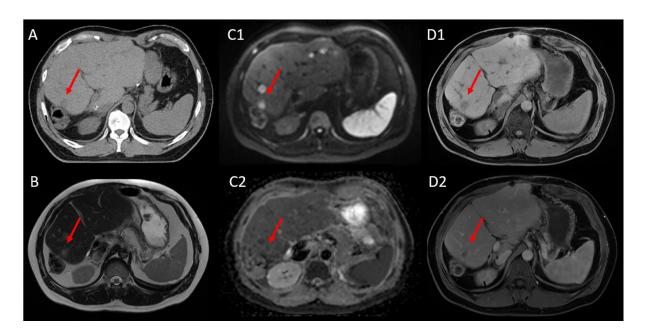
Treatment planning CT (A) and MRI (B-D): A patient with multiple liver metastases. A: native CT scan. B: T2 weighted sequence. C1: Diffusion-weighted Imaging (DWI) at the setting of b=900mm²/s. C2: Apparent Diffusion Coefficient (ADC at b50,900mm²/s). D: T1 weighted sequences with D1: native phase and D2: portal venous phase. Red arrows = demarcation of the target lesion.
